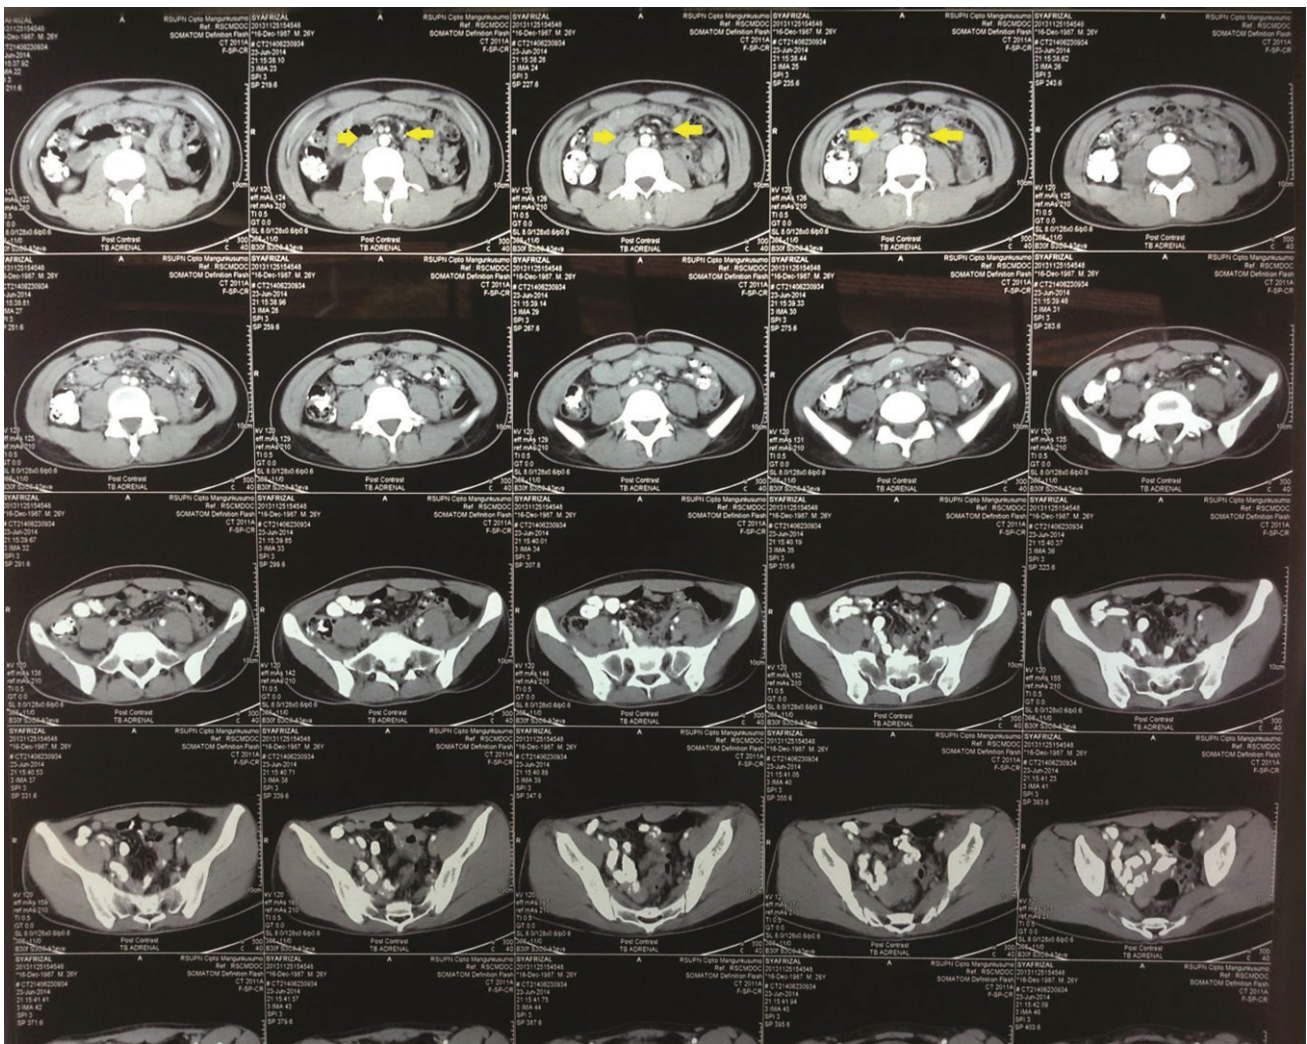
Adrenal CT scan of the patient showing normal adrenals.
